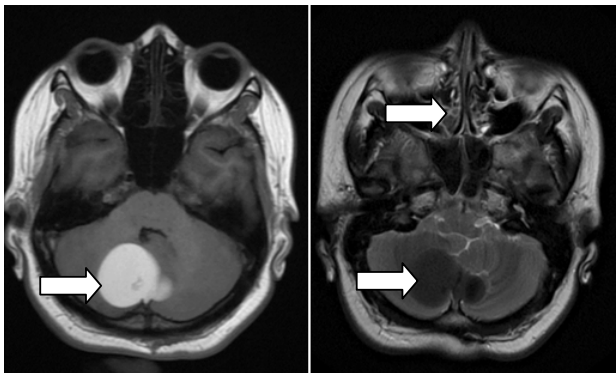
Magnetic resonance imaging - T1 weighted axial image showed hyper intense lesion (White arrow) in cisterna magna and T2 weighted axial image showed hypo intense lesion (White arrow) in the corresponding region.
